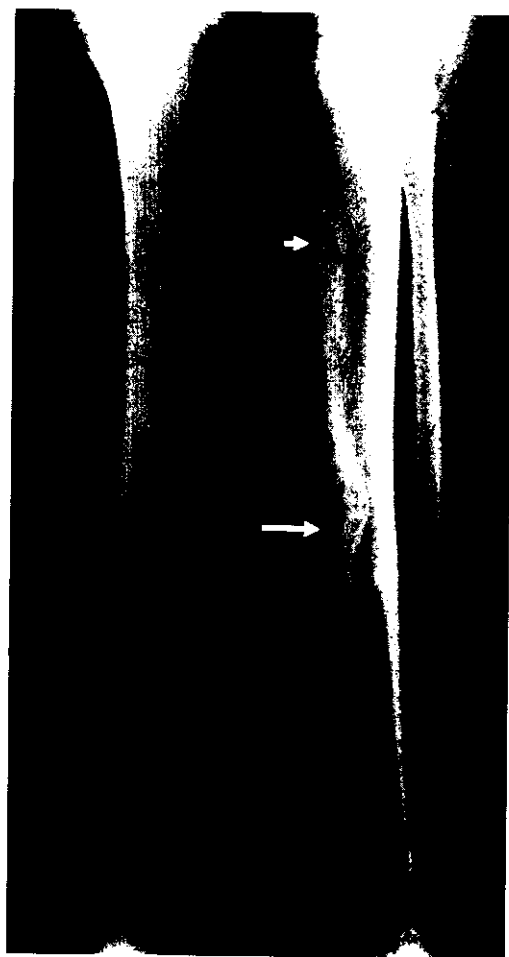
Case 1. Anteroposterior (AP) and lateral roentgenograms of the tibial midshaft of a nine-year-old girl. There is a lucent multilocular lesion with a sclerotic border on the anterior aspect of the midshaft, primarily involving the cortex (large arrow). A similar but smaller radiolucent lesion is seen on the upper one-third of the tibia (short arrow).
